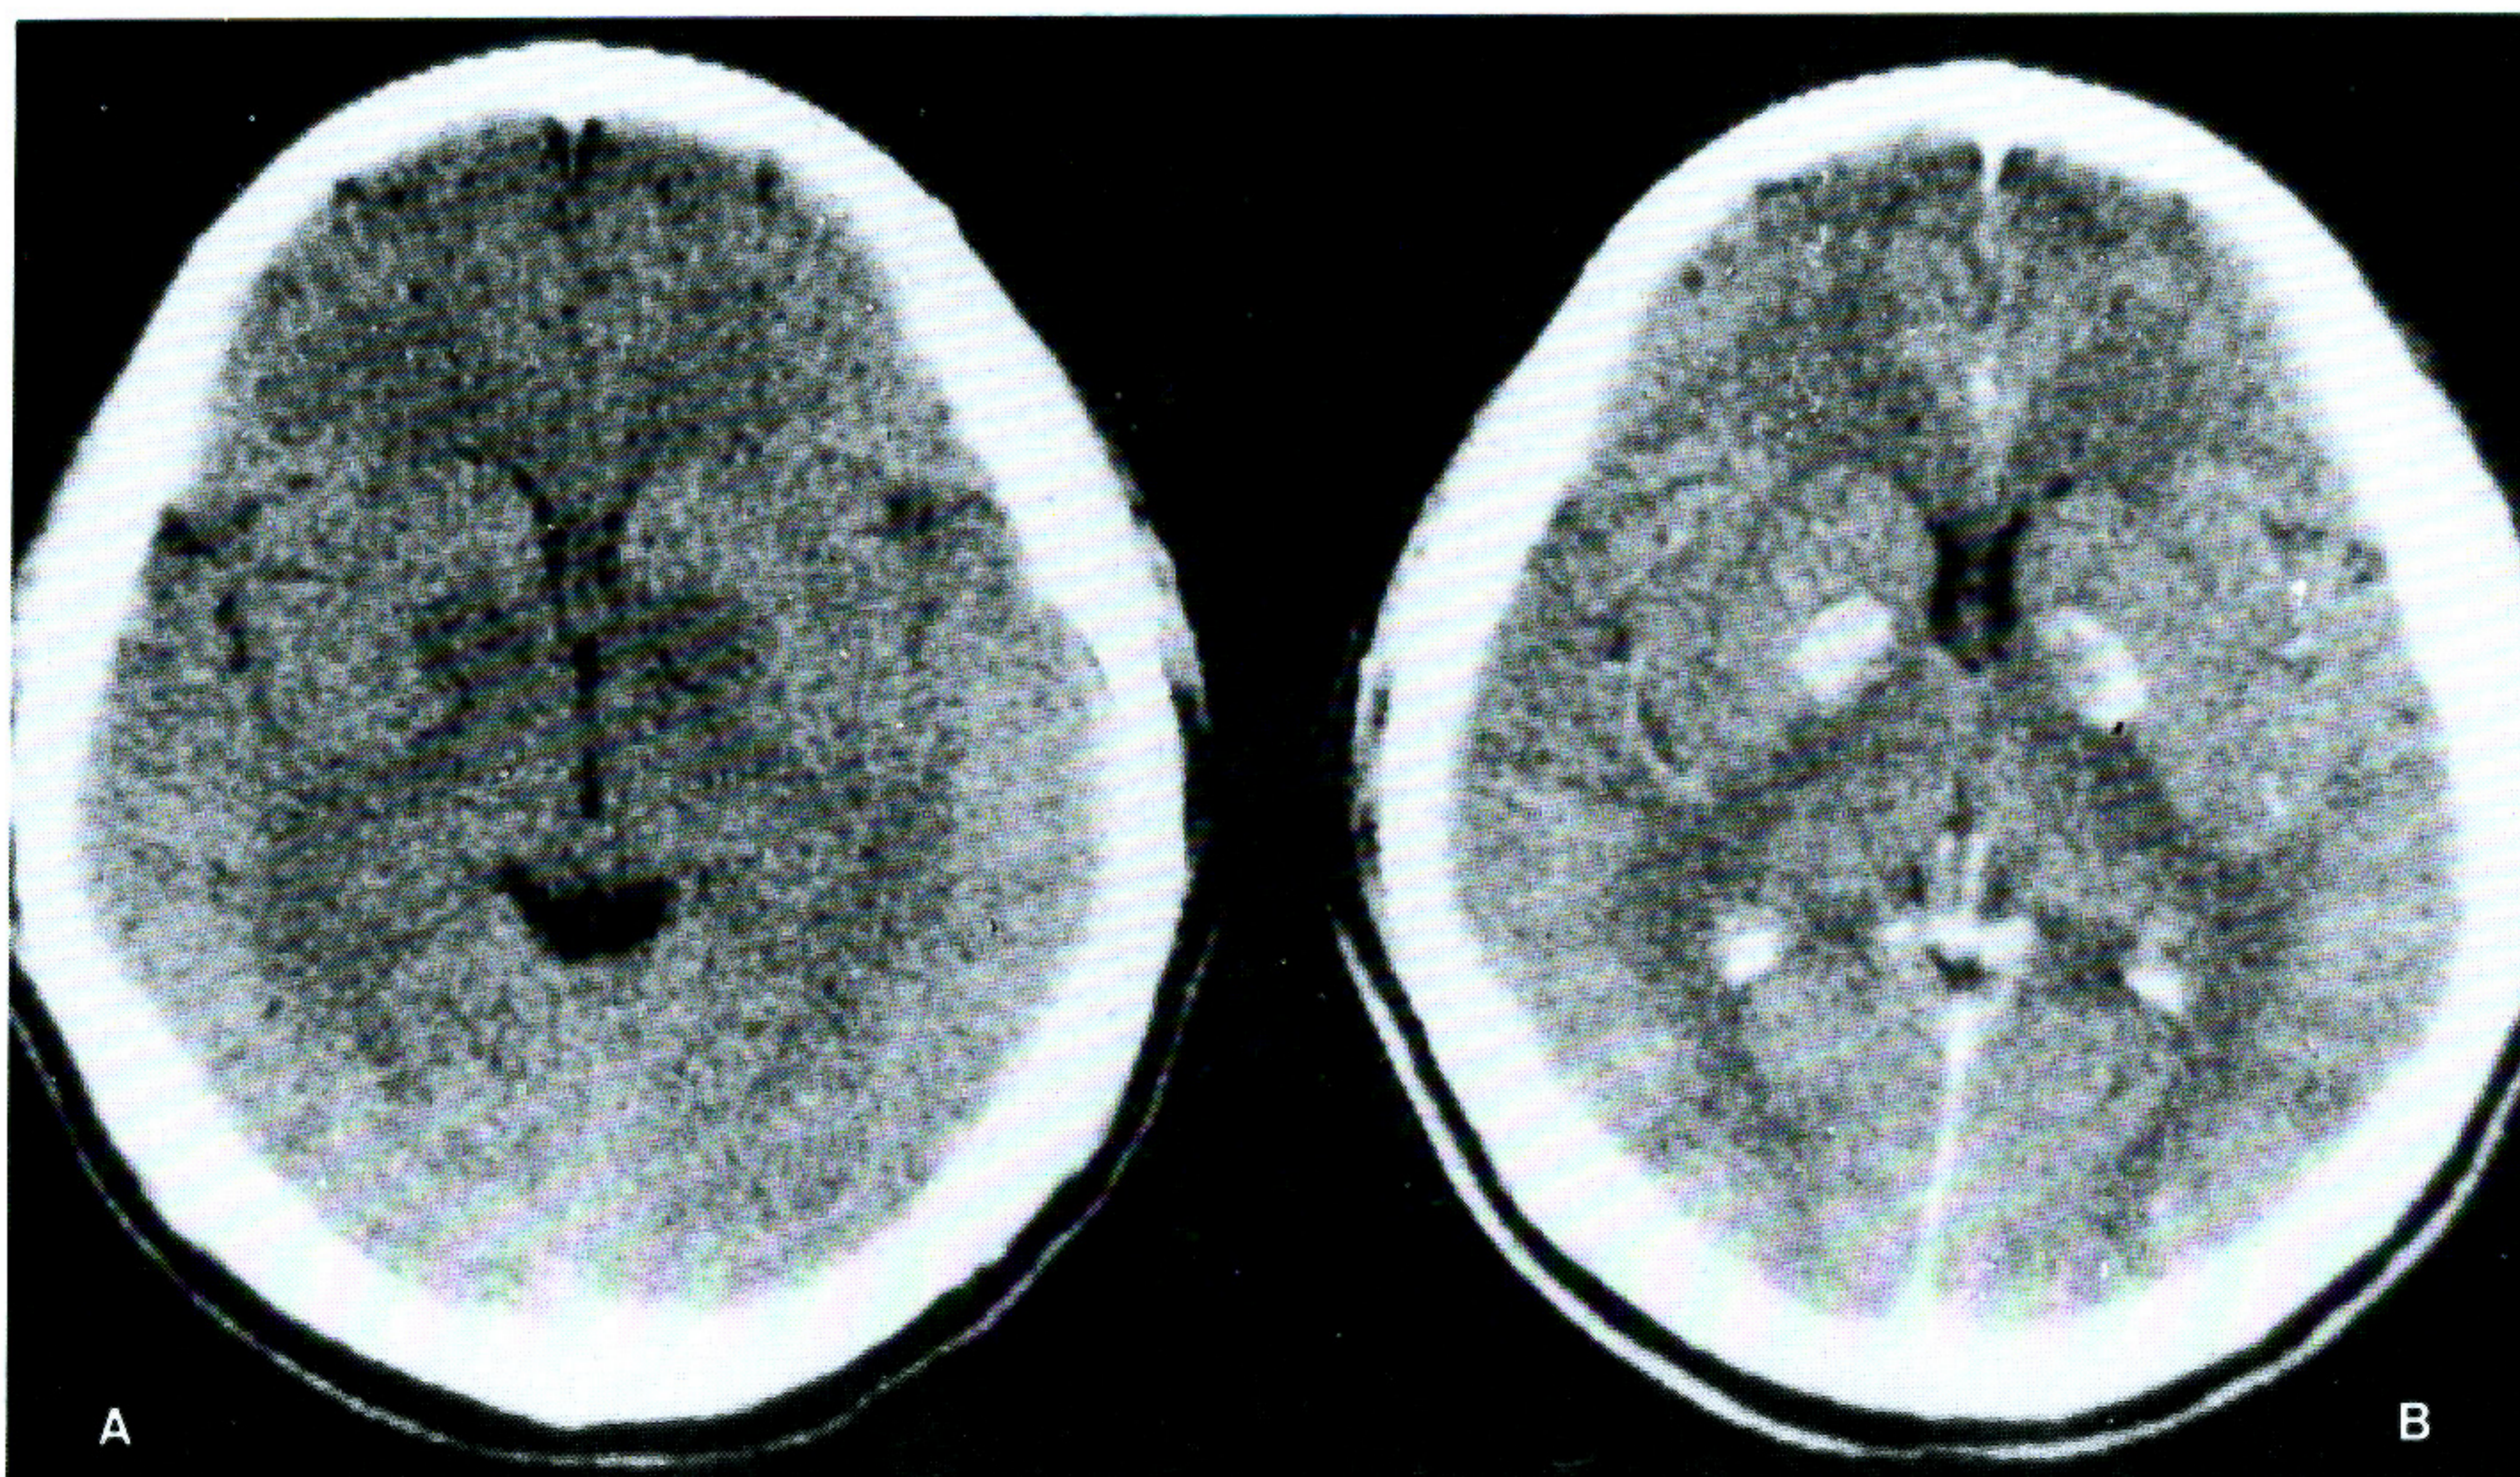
A. Pre-contrast CT scan 2 days after anoxia showed low-density in both globus pallidi. B. Post-contrast CT scan clearly demonstrated contrast enhancement in both globus pallidi.
